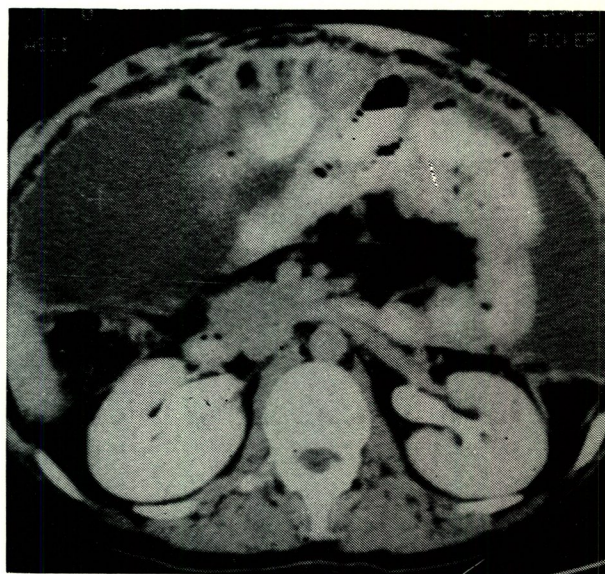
CT scan showing, ascites, matted bowel loops in the middle and posterior part of the abdominal cavity, with irregular parietal peritoneum anteriorly due to the tubercles.*
